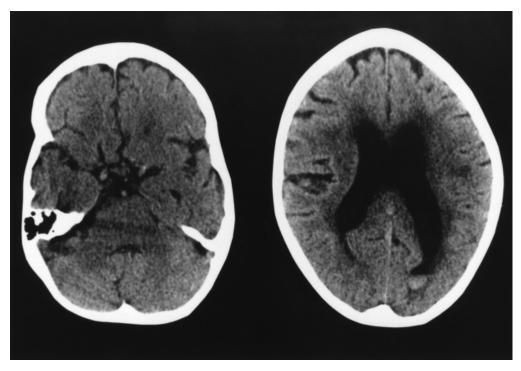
Sedimentation in the left occipital horn as the only sign of SAH on CT.
